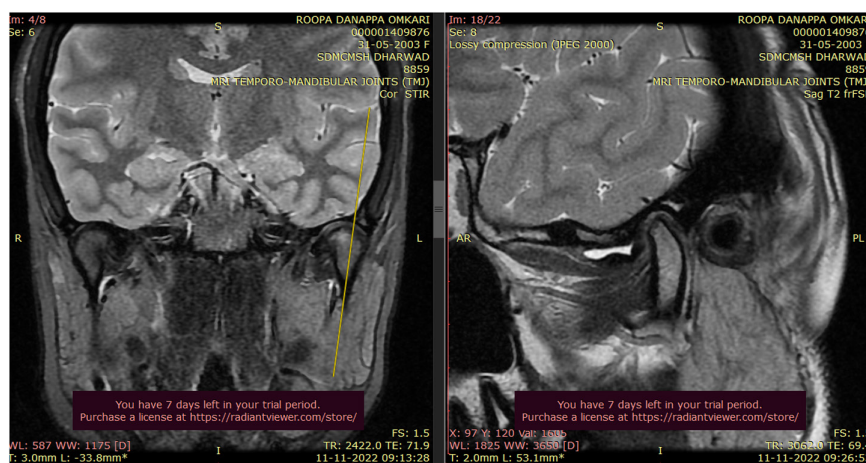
MRI showing disc-condylar complex in sagittal and coronal plane.
